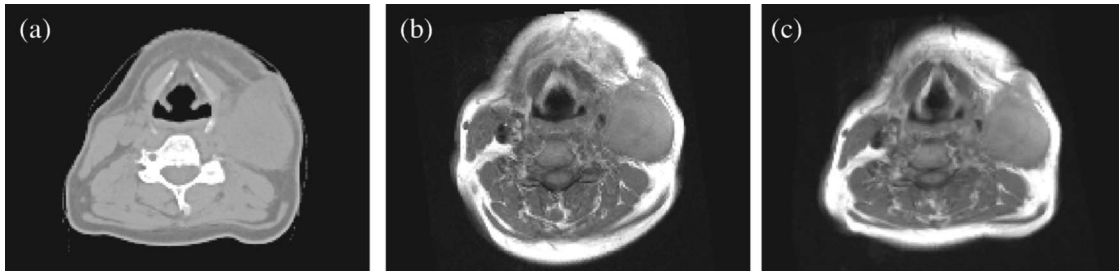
Exemplary CT-MRI head-and-neck registration: (a) CT as reference and (b)/(c) MRI as target image before/after registration.
